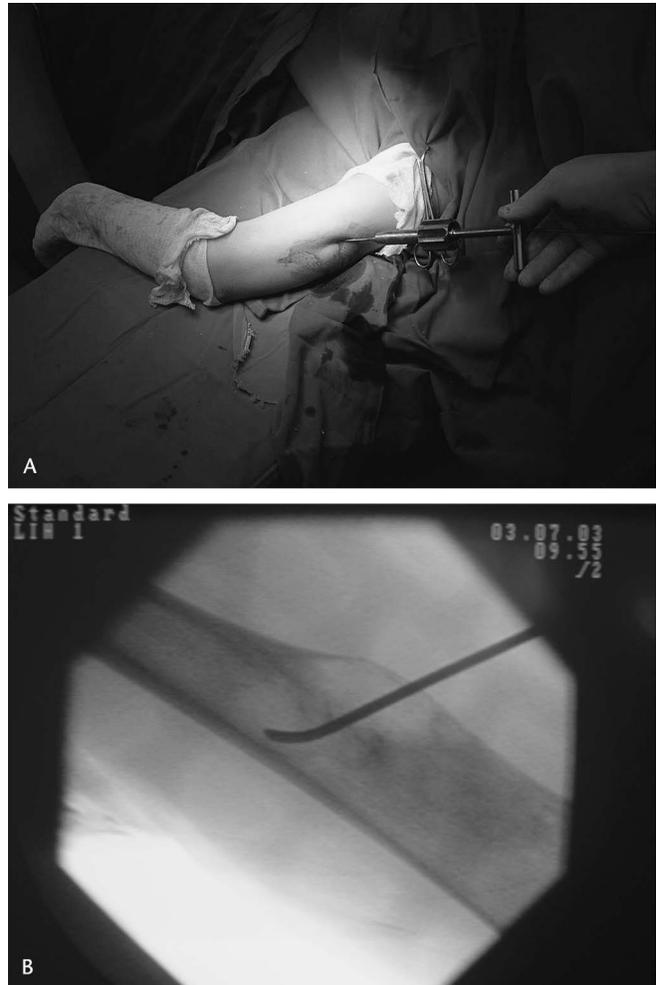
A, A titanium elastic nail attached to a cannulated T-handle is introduced into the cyst through the widened hole percutaneously. B, Intraoperative radiograph during percutaneous scraping of the cyst wall using a flexible titanium nail.
